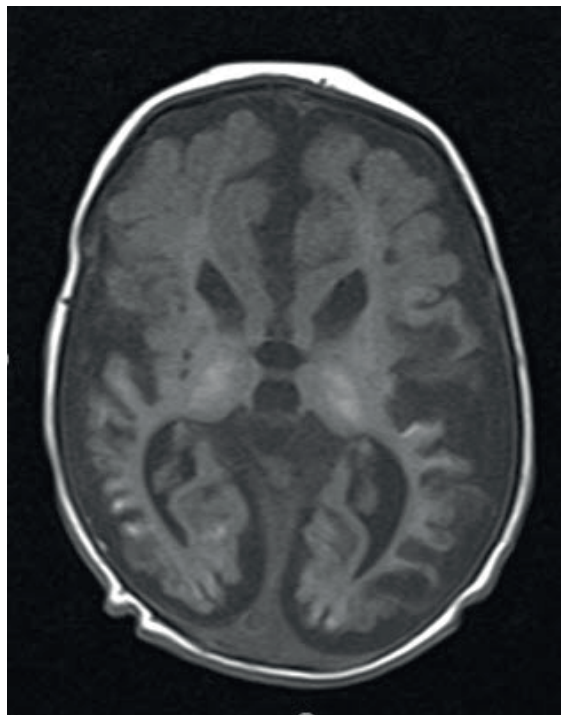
Coronal T1-weighted axial magnetic resonance imaging showing bilateral subcortical multi-cystic encephalomalacia mainly in the parieto-occipital regions with bilateral hyperintensities in the corticomedullary junction and thalamus.
